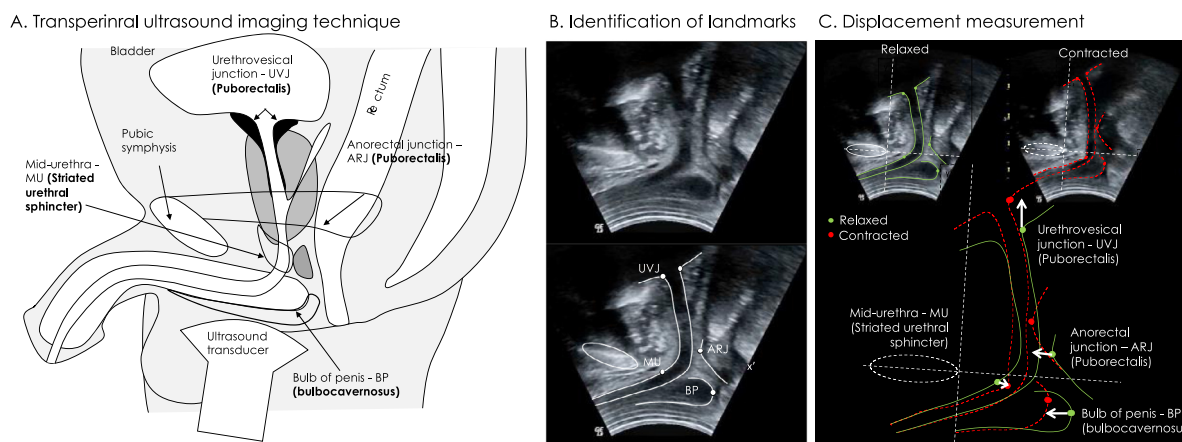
Technique for imaging and analysis of pelvic floor muscles with transperineal ultrasound imaging in men. (A) Imaging technique with the transducer placed in the mid sagittal line on the perineum between the anus and scrotum. (B) Placement of the axis system relative to the pubic symphysis and identification of the pelvic landmarks used to measure activation of each of the striated muscles of the pelvic floor. (C) Measurement of displacement of pelvic landmarks between rest and voluntary contraction of the pelvic floor muscles. ARJ = anorectal junction; BP = bulb of penis; MU = mid-urethra; UVJ = urethrovesical junction.
